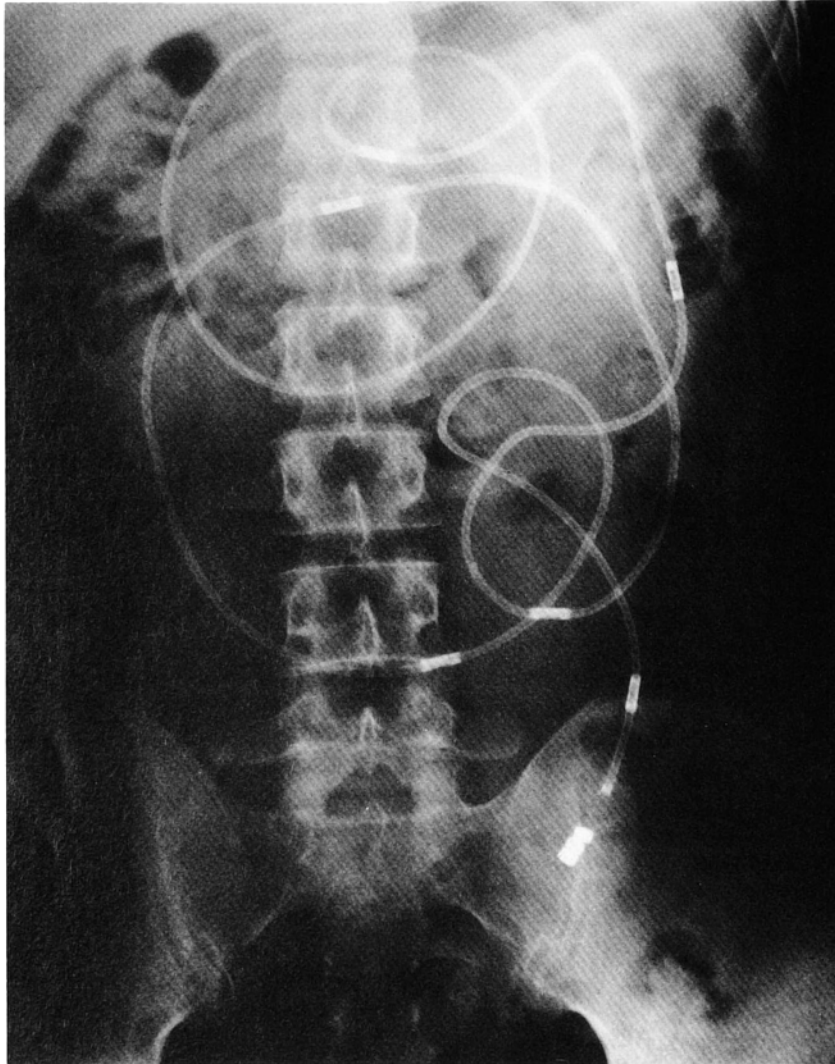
Abdominal radiograph showing motility catheter with six transducers positioned in the small intestine.
